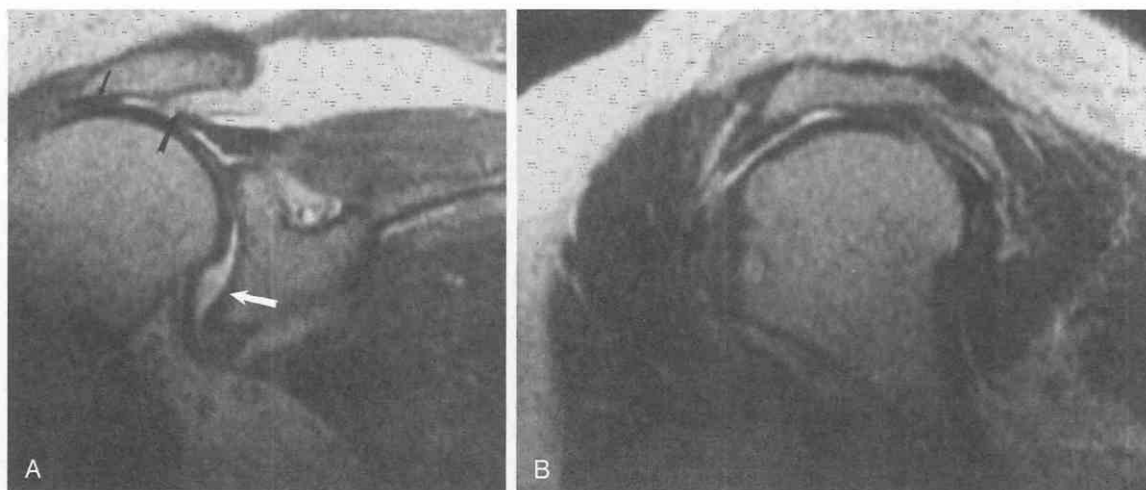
Large chronic cuff tear. *A*, T2-weighted (TR = 2500 msec, TE = 70 msec) coronal oblique image. Relatively little joint fluid is present. The supraspinatus tendon is retracted nearly to the glenoid (*black arrow*), and the humeral head has translated superiorly and contacts the acromion (*small black arrow*). Migration of the humeral head, leaving a partially empty glenoid fossa (*white arrow*), is one of the most obvious signs of rotator cuff tearing in this patient. *B*, T2-weighted (TR = 2500 msec, TE = 70 msec) sagittal oblique image. The acromion has a hooked shape. Note again the close apposition of the acromion and the humeral head.
